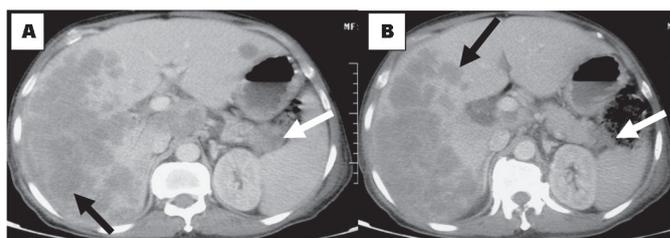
Computed tomography scan of abdomen showing pancreatic tail mass (white arrow) with hepatic metastasis (black arrow showing hypodense lesions).
